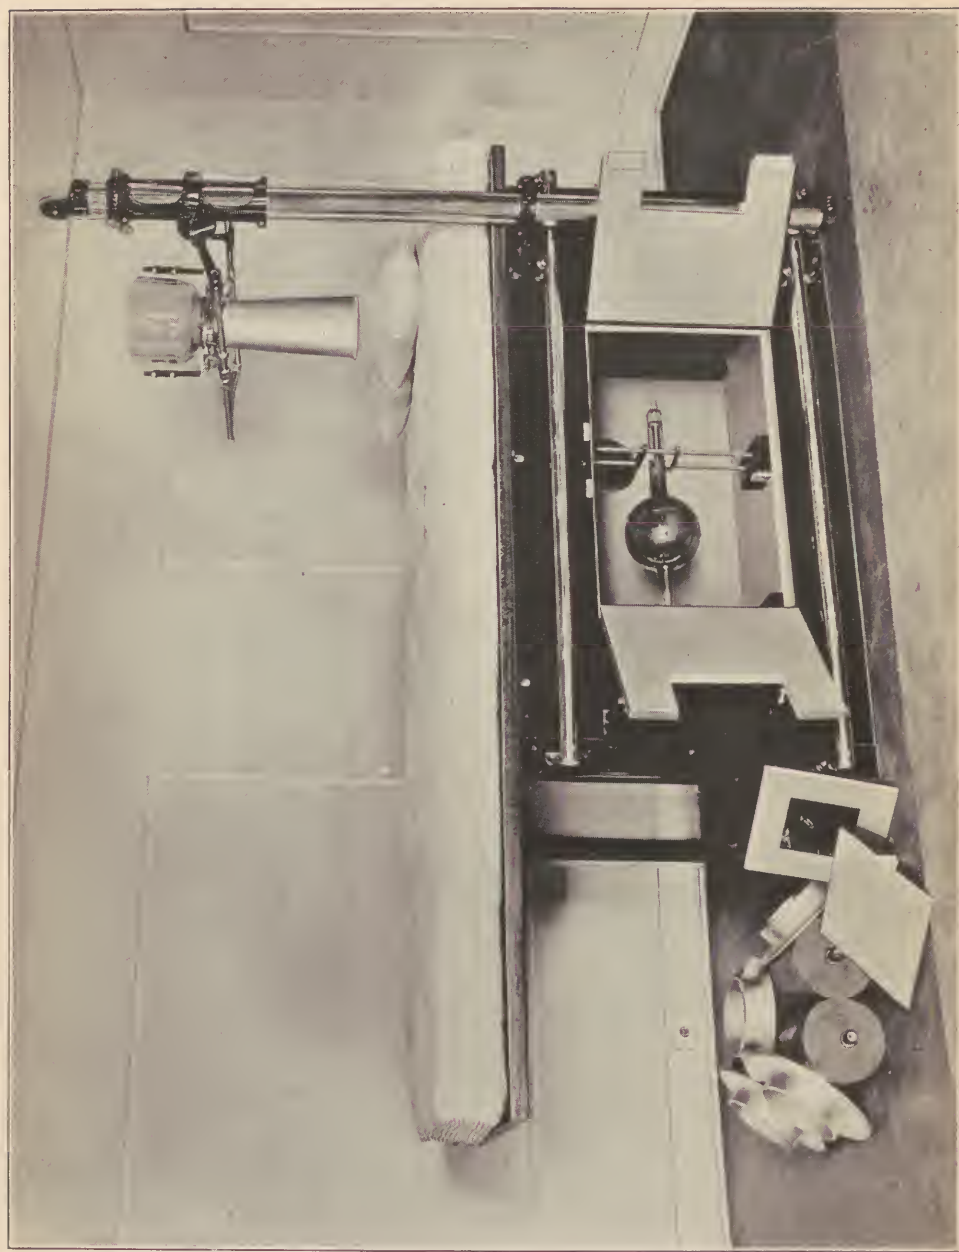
Tube Holder with Treatment Cone Attached to Couch, Designed and Built by the Standard X-Ray Company, Chicago, Ill.
